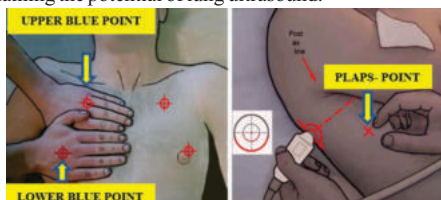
Probe positions for BLUE-protocol lung ultrasound: Anterior chest points for lung sliding and B-line evaluation (left), and posterolateral point for pleural effusion or consolidation detection (right).
